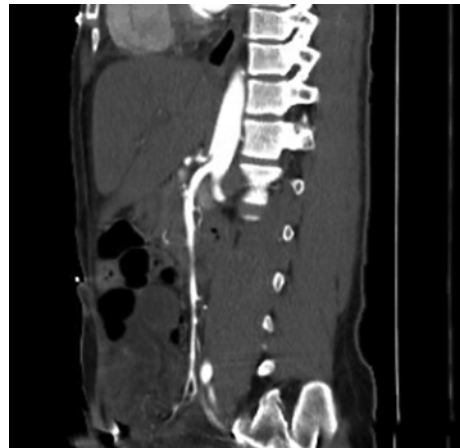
CT scan of the abdomen and pelvis with intravenous contrast demonstrating mild compression of the celiac artery.
